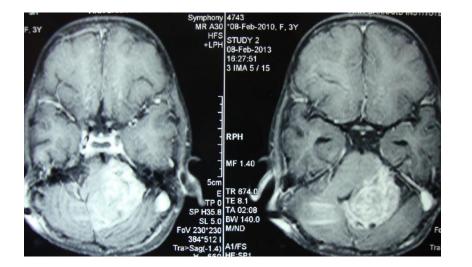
MRI BRAIN OF THE SAME PATIENT SHOWING ENHANCING LESION IN THE MIDLINE WITH EXTENSION INTO LEFT SIDE DISPLACING FOURTH VENTRICLE TO OPPOSITE.
